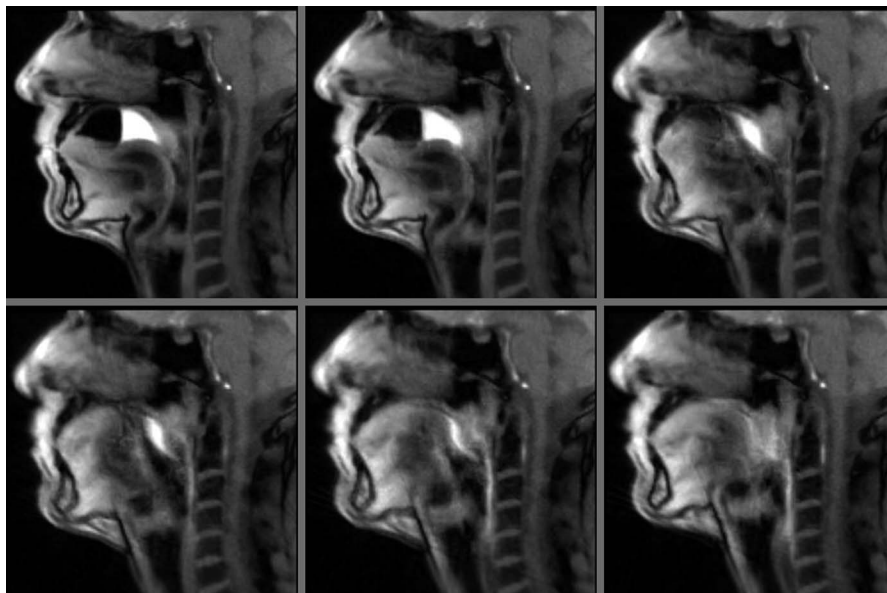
Swallowing. Selected frames (midsagittal views from top left to bottom right) of a real-time MRI movie of the oral cavity during a voluntary swallow of 5 mL pineapple juice (40 milliseconds acquisition time, 1.3 mm resolution, 8 mm slice thickness). The frames are 2 images apart (80 milliseconds) and cover the swallowing process (480 milliseconds) from initiation to esophageal transport.
